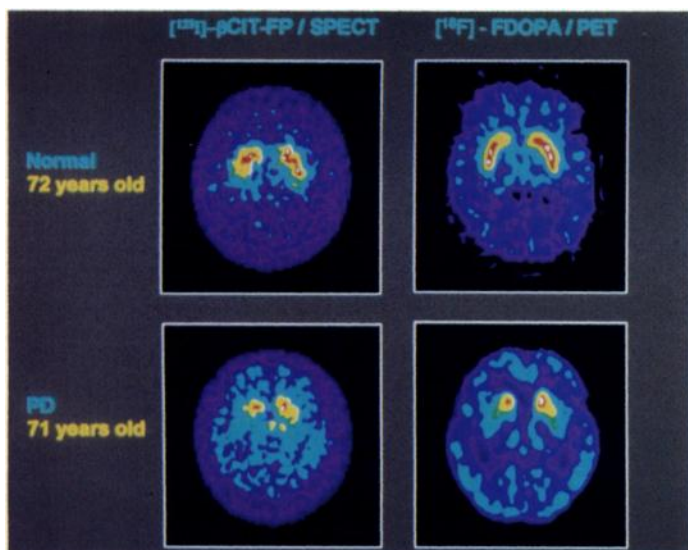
Left: β CIT-FP SPECT images from a 72-yr-old normal volunteer (top) and a 71-yr-old patient with H&Y Stage I PD (bottom). Right: FDOPA PET images from the same subjects. In the parkinsonian patient, both PET and SPECT show a comparable 55% reduction in striatal radiotracer uptake localized primarily to the left putamen.
